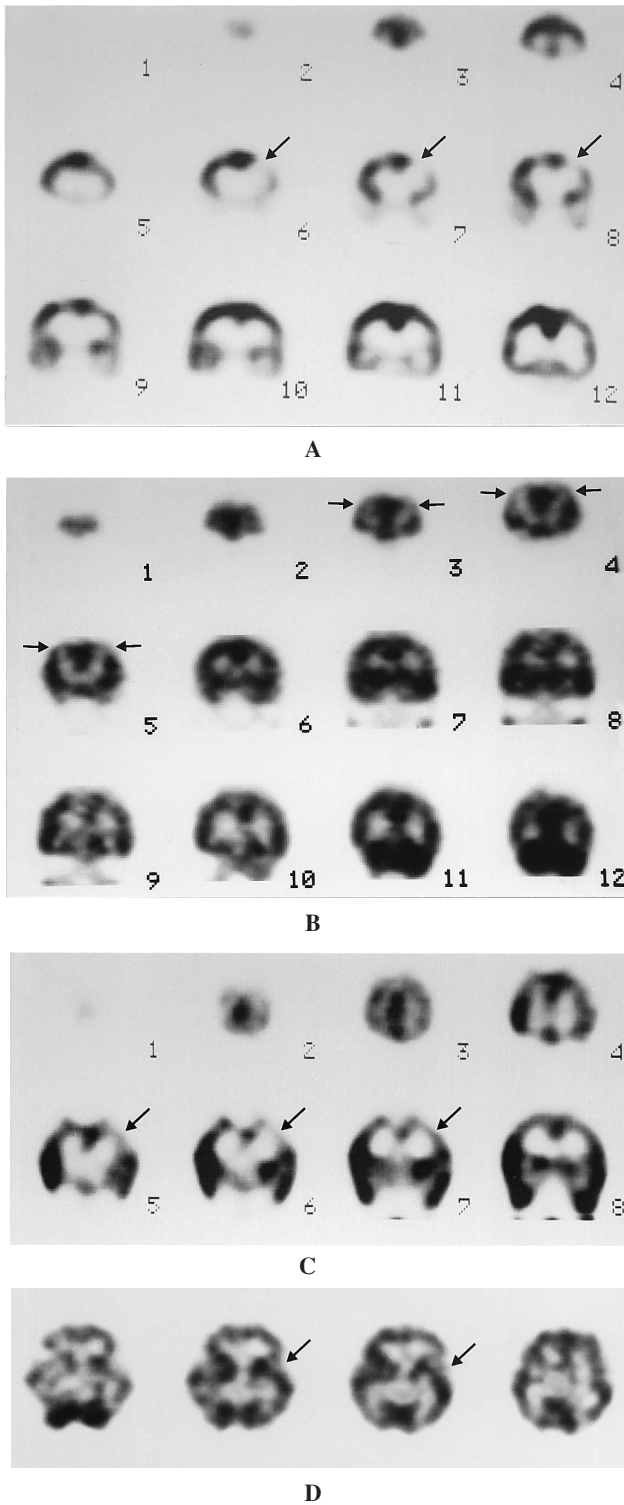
Representative Tc-99m HMPAO SPECT images of brain perfusion abnormalities in COPD patients. (A) SPECT shows reduced cerebral perfusion in left frontal region (*arrow*) in a 55-year-old man with nonhypoxemic COPD. (B) Images of Tc-99m HMPAO shows bilateral hypoperfusion of frontal regions (*arrows*) in a hypoxemic patient. (C) Coronal views of the brain of a 36-year-old woman with hypoxemic COPD shows hypoperfusion of left parietal region (*arrow*). (D) Selected transaxial slices in a hypoxemic patients reveals decreased perfusion in left temporo-parietal region.
